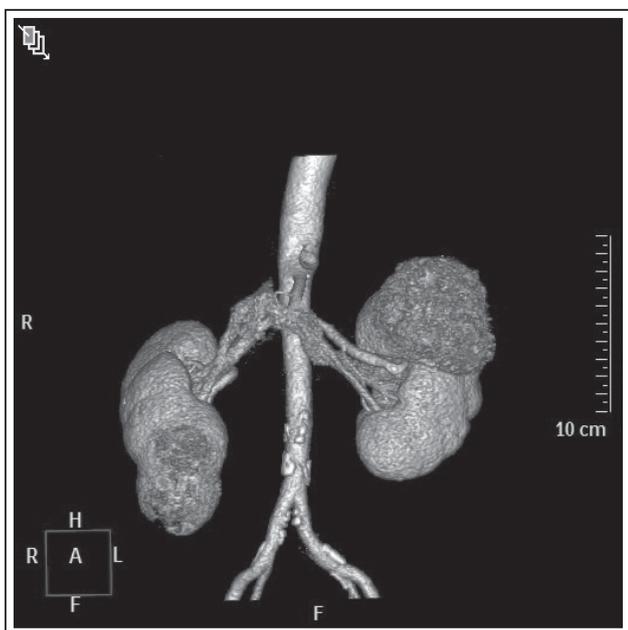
CT reconstruction of bilateral renal masses in Patient 2.
